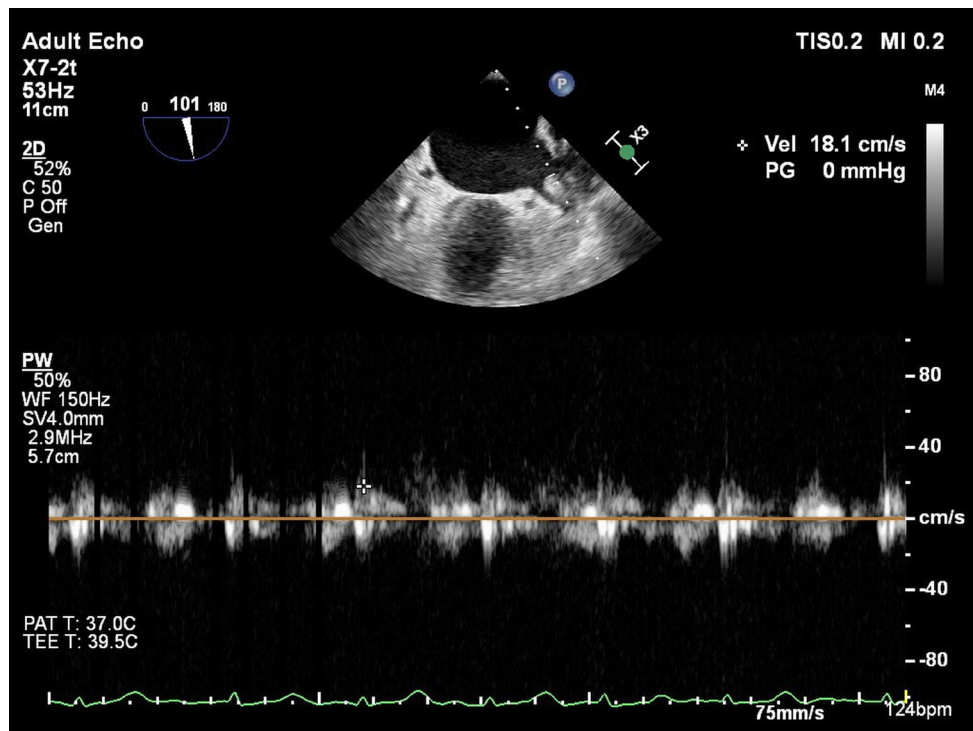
LAA thrombus formation and measurement of the LAA emptying velocity from the orifice on two-dimensional transesophageal echocardiography.
